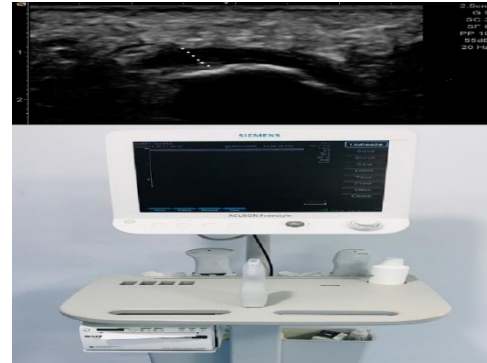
Ultrasound- guided measurement of plantar fascia thickness (white dots) and Acuson Freestyle Ultrasound System, Siemens .
